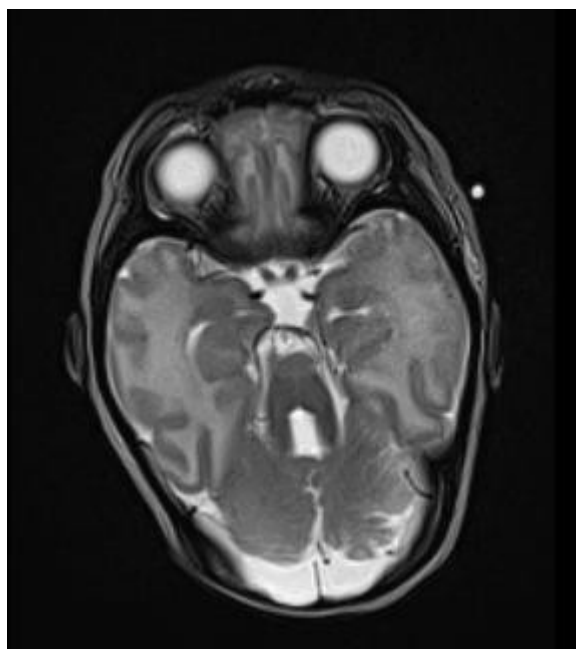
Axial brain MRI showing features of JS: thick, elongated and abnormally oriented superior cerebellar peduncles and deepened interpeduncular fossa compose a MTS (Patient I).
